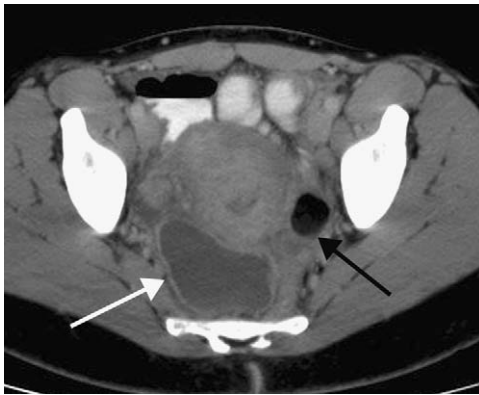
Pyosalpinx. Enhanced computed tomography shows a pyosalpinx (white arrow) with indistinctness of the adjacent pelvic fat and soft tissues. An incidental fat-containing mature teratoma (black arrow) is seen on the left side.
